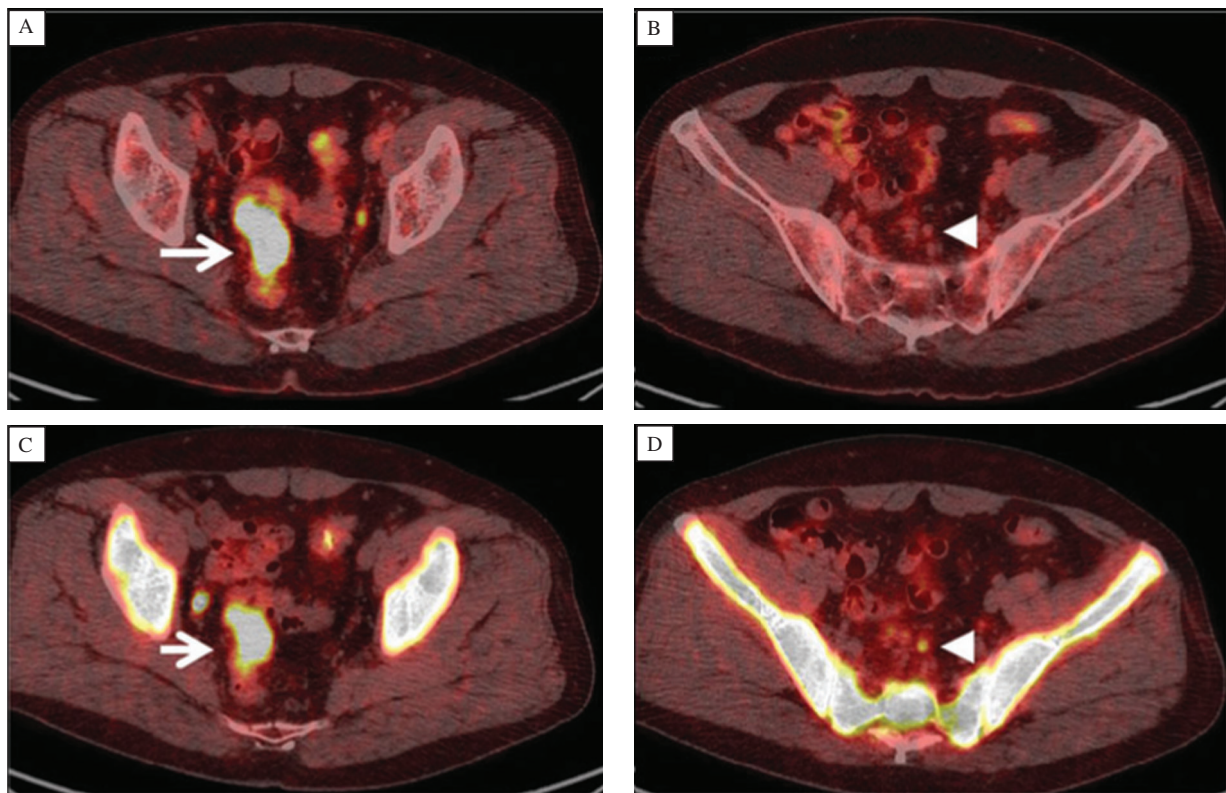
A case of rectal cancer with regional metastatic lymph nodes in a 58-year-old man (with permission from reference 29). A and B: ^{18}F -FDG PET/CT imaging displays positive ^{18}F -FDG uptake in the rectal cancer (SUVmax 25.1, arrow), and negative ^{18}F -FDG uptake in a metastatic regional lymph node (arrowhead). C and D: ^{18}F -FLT PET/CT images show positive ^{18}F -FLT uptake in the rectal cancer (SUV max 7.7, arrow) and in the metastatic regional lymph node (arrowhead).
